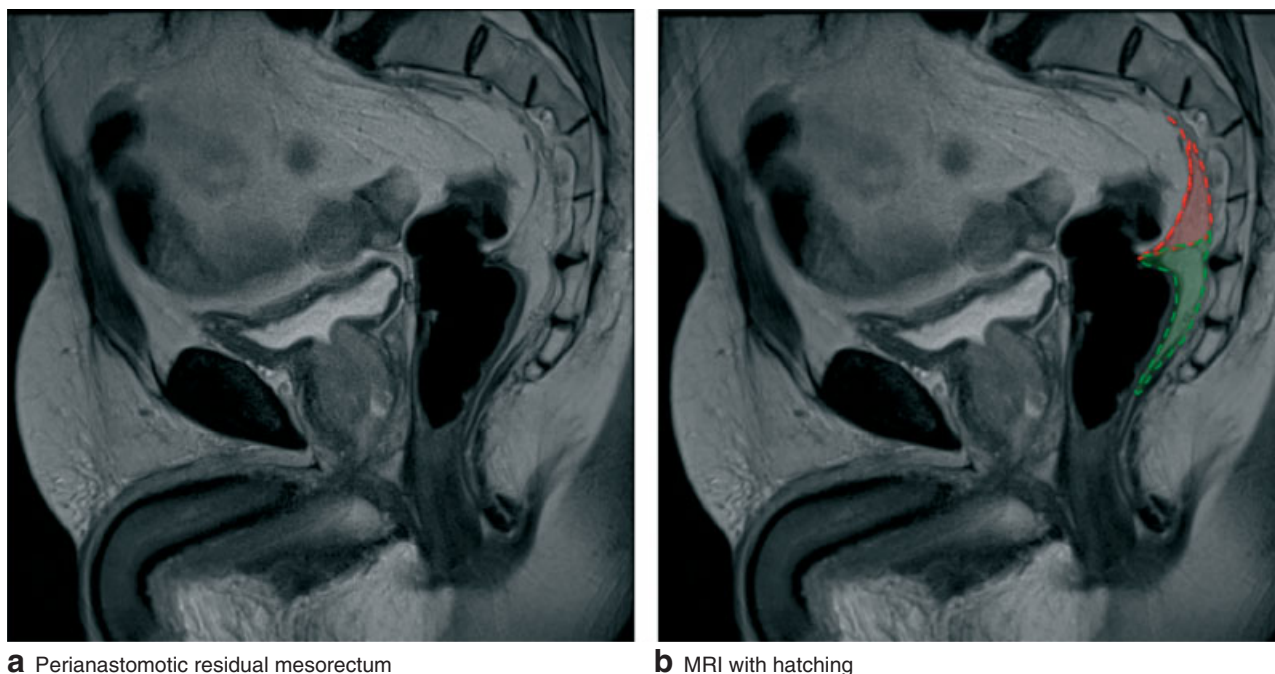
Inadvertent residual mesorectum after partial mesorectal excision. a,b Sagittal T2-weighted images showing perianastomotic residual mesorectum above the level of the anastomosis (hatched with red in b). b Green zone shows intended residual mesorectum below the level of resection. MRI, magnetic resonance imaging
